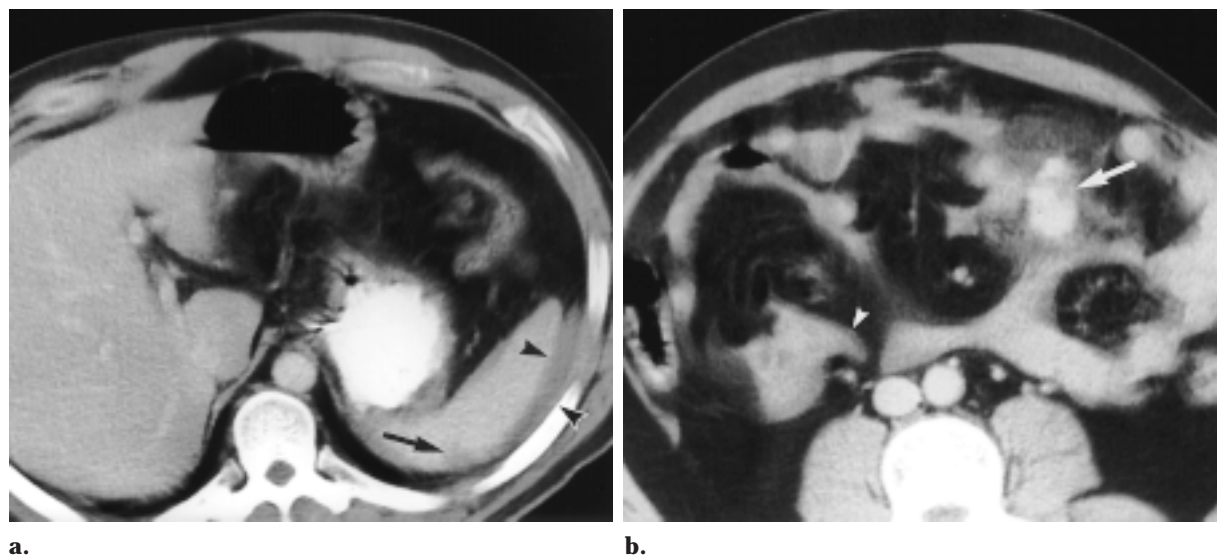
Splenic and mesenteric lacerations in a 41-year-old man. (a) Abdominal CT scan reveals a splenic laceration (arrow), which contributed to hemoperitoneum (arrowheads). (b) CT scan obtained at a lower level shows a focus of contrast material extravasation (arrow) and adjacent stranding, findings that help identify the mesenteric laceration. (Note: A low rate of intravenous administration of contrast material results in faint attenuation of the contrast material extravasation.) Adjacent interloop fluid (arrowhead) is present.
